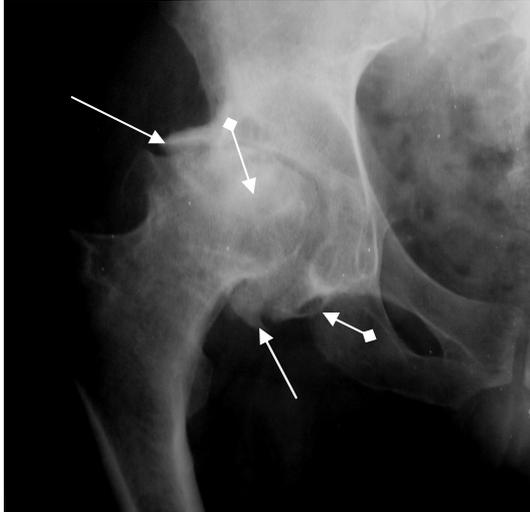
Enlargement radiograph of the right hip joint in a direct projection. Narrowing and deformation of joint, osteophytes (arrows), subchondral sclerosis, degenerative synovial cysts are detected in both femoral head and acetabulum (arrows with rhombus) is indicated. Osteoarthritis of the hip joint is detected.
